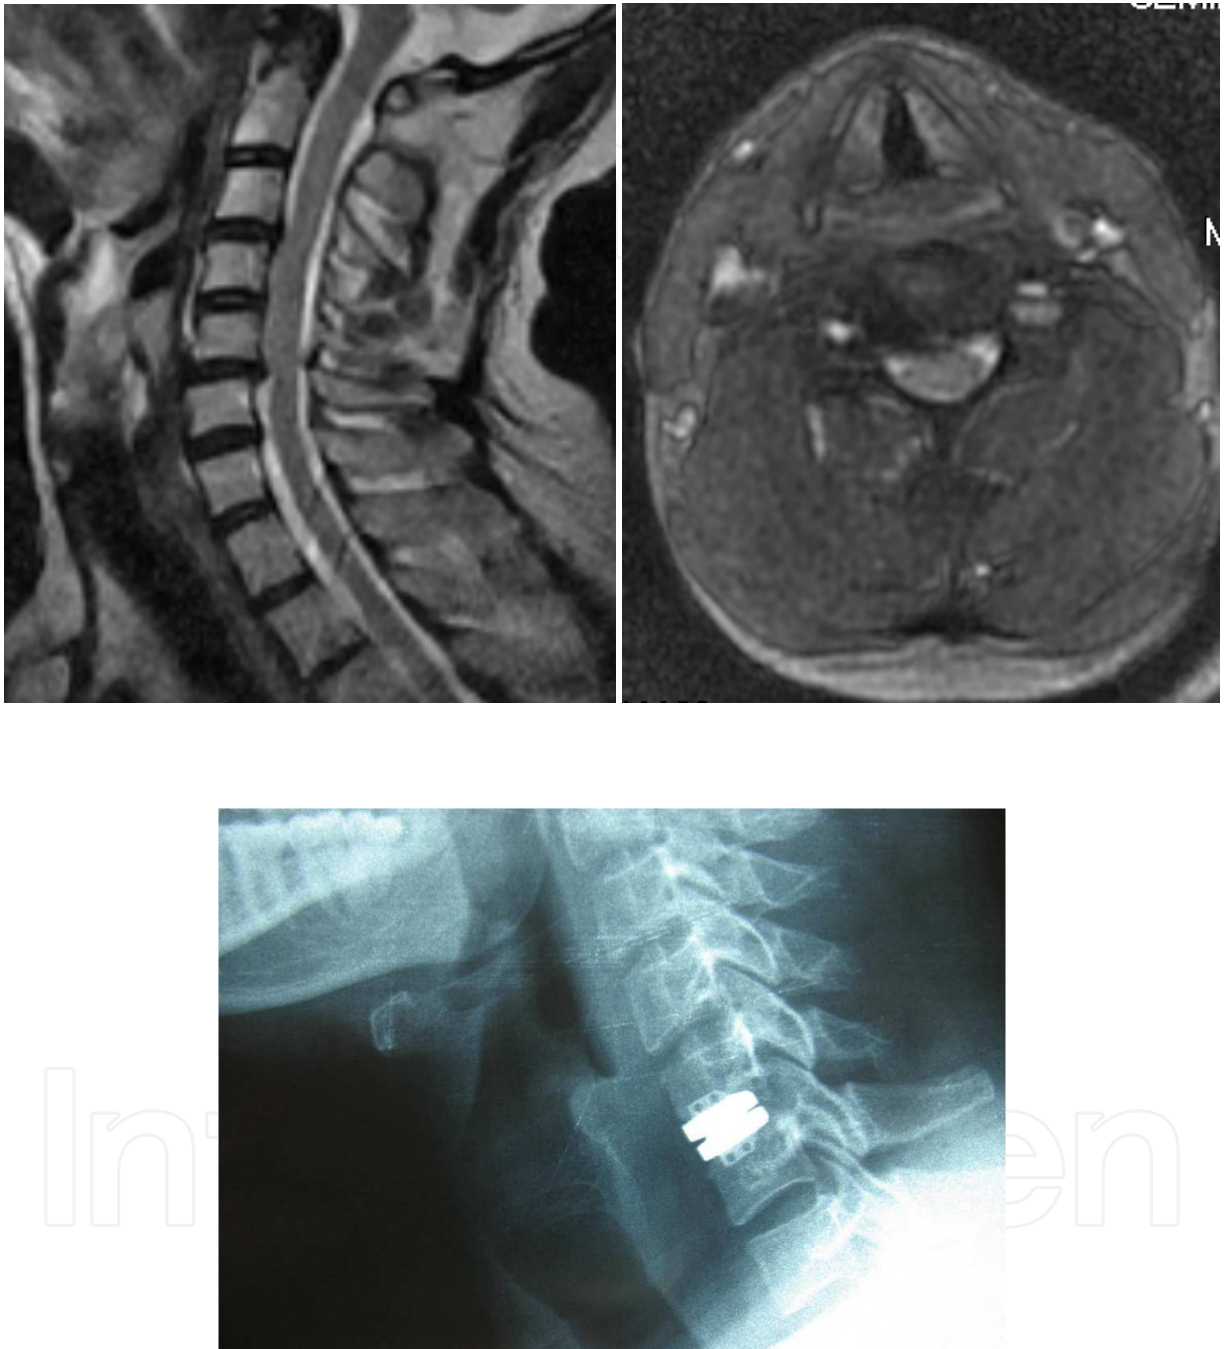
Preoperative servical MRI was shown with C5-C6 servical degenerative disc hernia. 39 year-old male subject was admitted with right arm pain and numbness for three months period. At physical examination left C5-6-7 sensation lost, muscle weakness and biceps reflex hipoactivity were observed. Patient was operated and applicated Maverick artificial disc prosthesis at C5-C6 level (Karabekir, 2010). Artificial disk was shown at postoperative direct x-ray.
